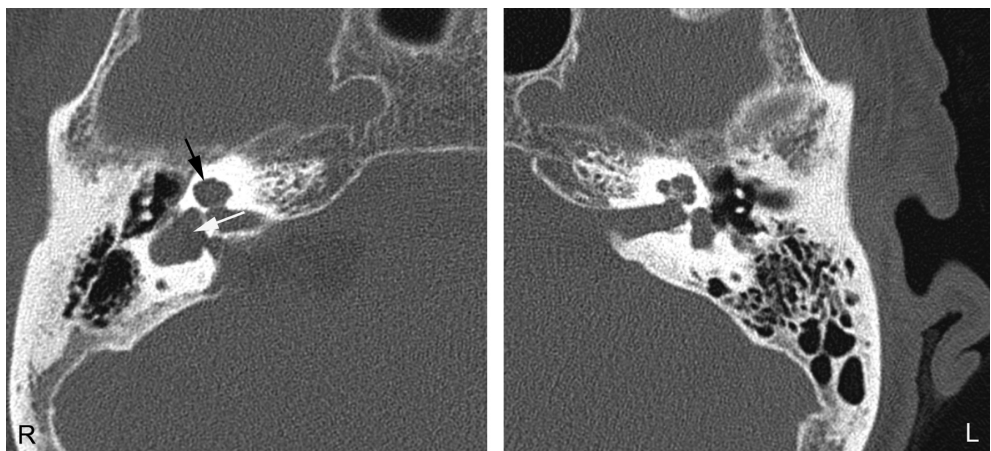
Axial computed tomographic image of the inner ear, bone window. In the right inner ear (R), an enlarged vestibule that incorporates the lateral semicircular canal is seen (white arrow). Also, the cochlea shows incomplete partition, with the upper turns forming a common cavity (black arrow), and there is absence of the modiolus. In comparison, in the left inner ear (L), a normal anatomy of the cochlea is seen. The findings on the right side are characteristic for cystic cochleovestibular malformation (incomplete partition type I).
